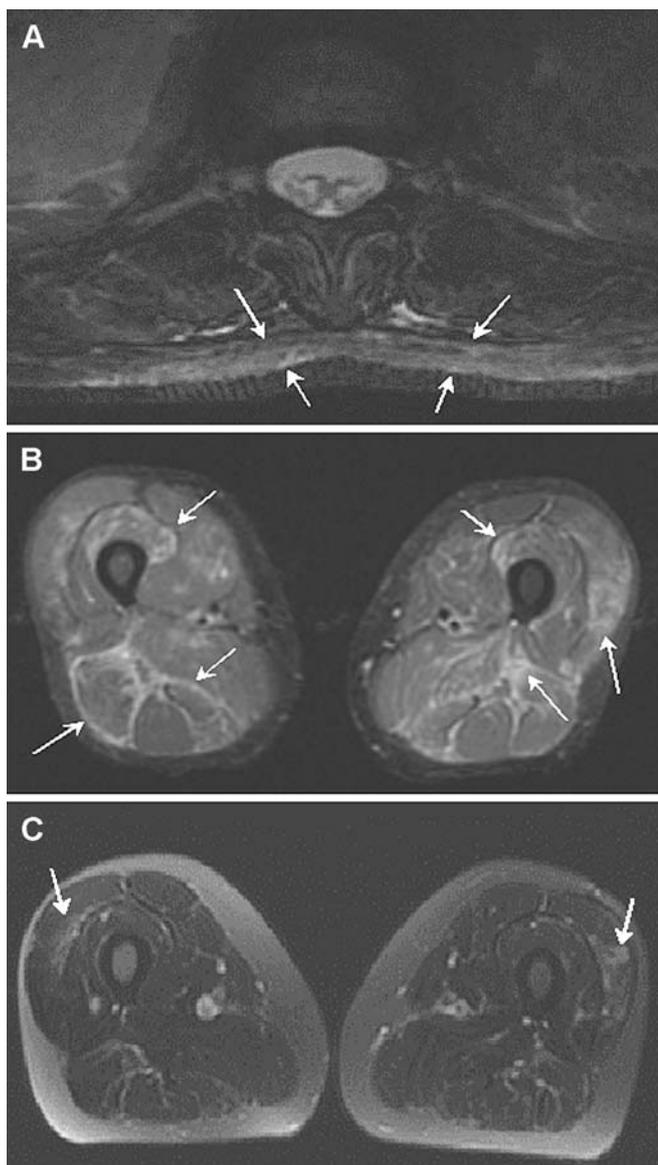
Magnetic Resonance Imaging: A) Inversion recovery (IR) axial thoracic spine demonstrates skin thickening and edema signal in subcutaneous tissue (arrows); B) axial IR bilateral thigh muscles before cyclophosphamide (CYC) with bilateral edema-like signal in the muscles and fascia (arrows); C) axial bilateral thighs fat suppressed T2 weighted images after 6 months of CYC demonstrates near complete resolution of the edema signal, with mild residual signal in the vastus lateralis (arrows)
